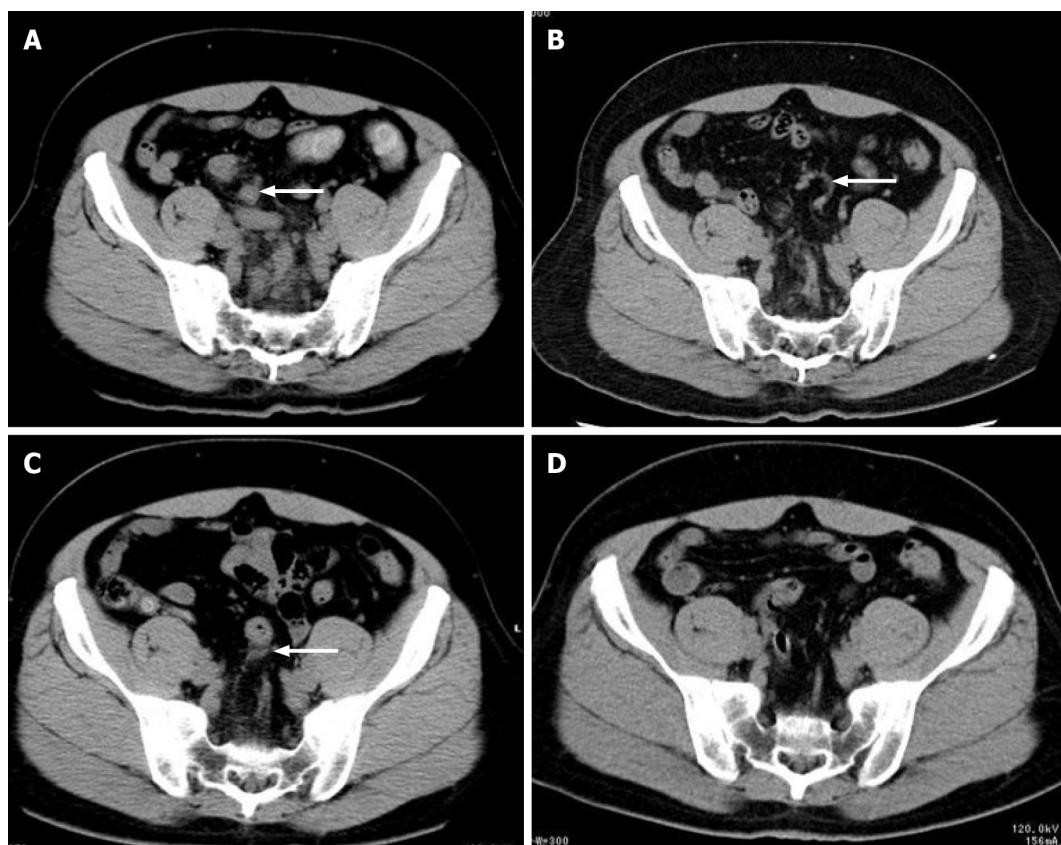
Recent abdominal computed tomography. A-D: Non-enhanced abdominal computed tomography images were taken before admission (A) and 2 years (B), 5 years (C), and 8 years (D) ago. The vessels around the rectosigmoid colon were not evident 8 years ago (D), but dilation of blood vessels around the rectosigmoid colon could have been detected 5 years ago (B and C).
